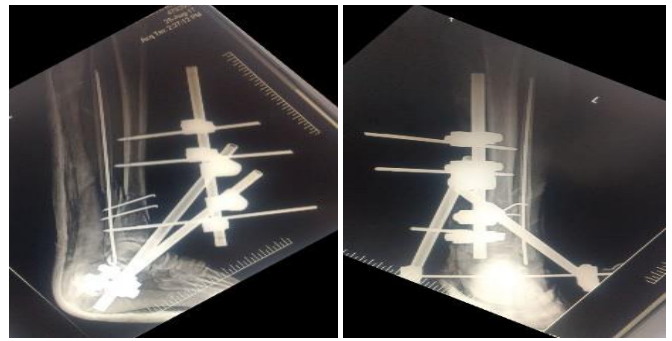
Immediate postop x-ray AP view Lateral View
